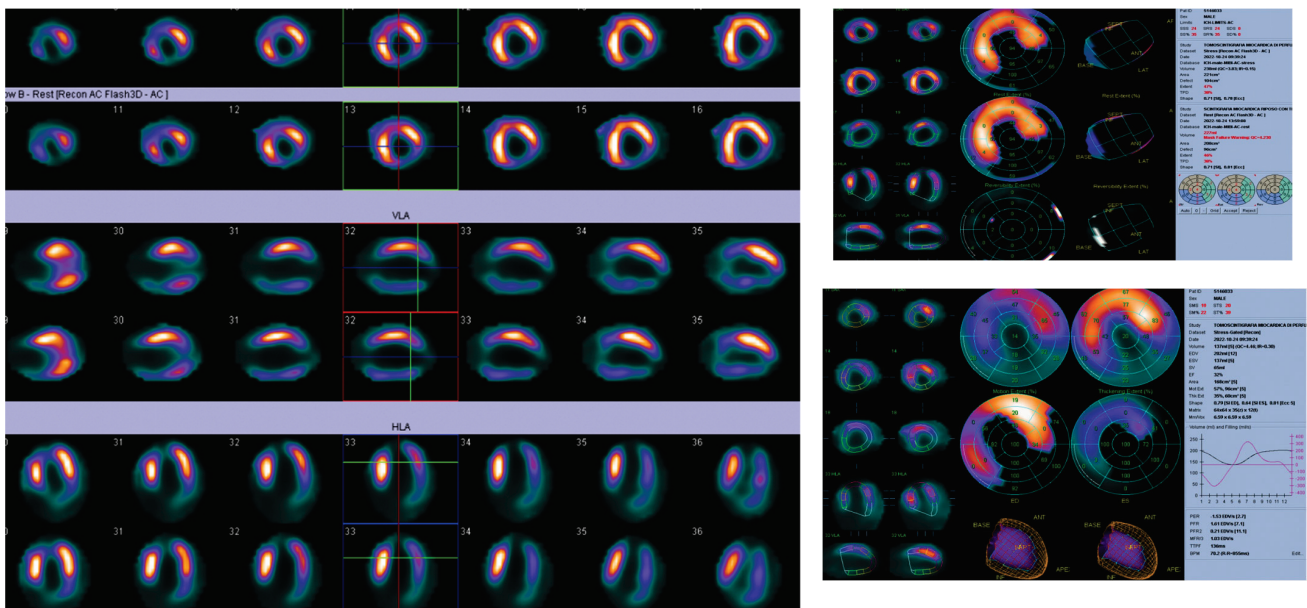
Stress/rest myocardial scintigraphy revealed the absence of myocardial ischemia but necrotic areas in the apical, inferior, and lateral walls were detected. The ejection fraction was measured at 32% after stress, and significant alterations were noted in wall motion and wall thickening in the same regions.
